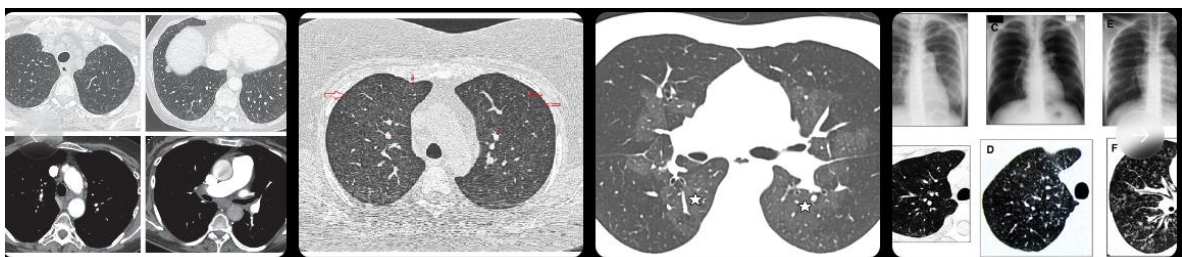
Axial high-resolution chest CT images showing centrilobular ground-glass opacities, septal thickening, and mediastinal lymphadenopathy—a radiological triad highly suggestive of PVOD
